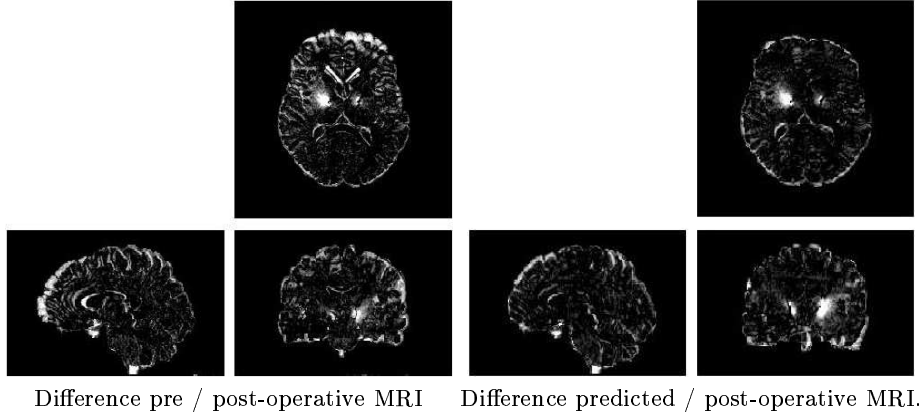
presents the absolute difference of pre and post-operative MRI compared to the absolute difference of predicted and post-operative MRI. The predicted MRI have been computed with the two CSF liquid levels that minimize the global error with the post operative MRI. We can verify that our model is able to balance the brain shift phenomenon as well as the asymmetry. Nevertheless, the model does not seem to reduce the difference residue on the sulcus area. This problem is, in our opinion, due to the homogeneous material model proposed for the full brain and maybe also to displacement boundary conditions imposed at the base of the occipital lobe.
